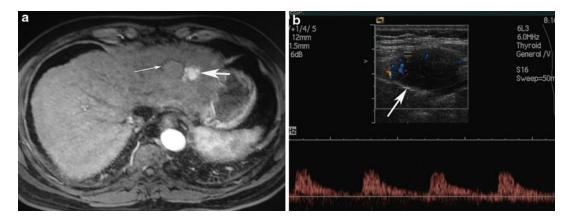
Suboptimal clinical outcomes and complications of MWA for HCC. (a) Nodular hyperattenuation consistent with recurrence (*thick arrow*) was detected by contrast-enhanced MRI in the peripheral ablation zone (*thin arrow*) 6 months after MWA for left lobe HCC which was treated by another MWA. (b) Tumor seeding in a 44-year-old man with HCC in the abdominal wall.
